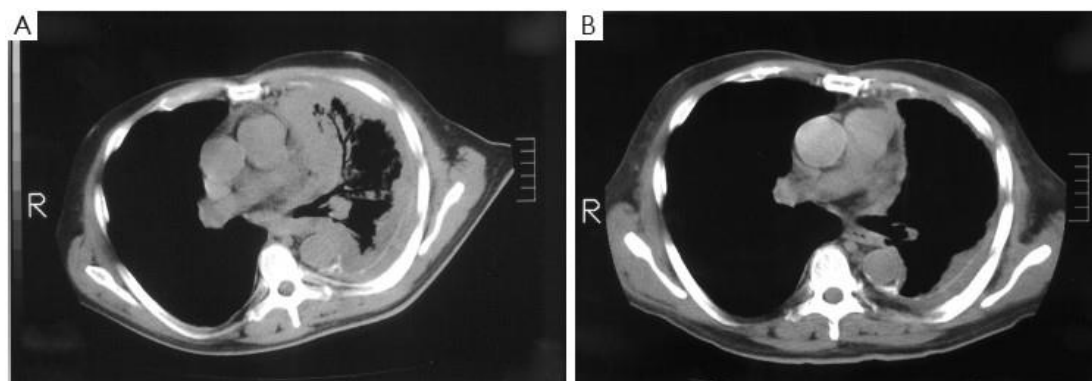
Axial computed tomography (CT) scan. Scan shows pre-treatment disease (A) and a partial response to chemotherapy with cisplatin and pemetrexed (B) after four cycles of treatment (adapted from Nowak (63)).
